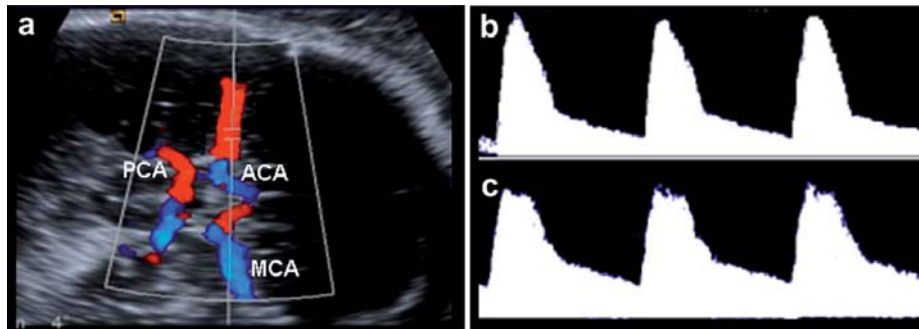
Color Doppler assessment of the middle cerebral artery at the level of the circle of Willis (a). Normal (b) and abnormal (high diastolic velocities and decreased pulsatility index) (c) waveforms. (20)
